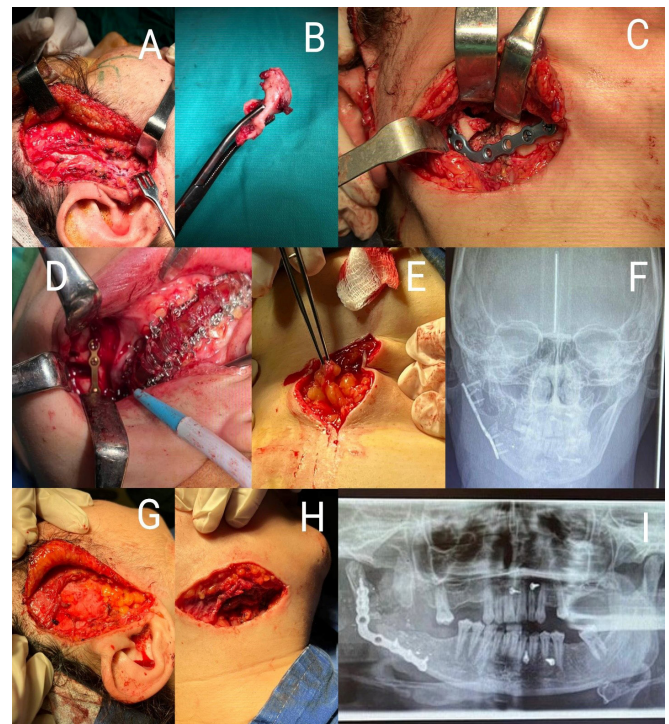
(A) Preauricular incision and access to the infratemporal fossa. (B) The mandible condyle after separating from coronoid process. (C) reconstructing condyle to the mandible corpus using reconstruction palate. (D) closed reduction maxillomandibular fixation. (E) Harvesting fat graft from abdominal dermis. (F) A post-Operative posteroanterior radiography. (G) Filling the preauricular region by the fat autograft. (H) Filling the region of submandibular incision by the fat autograft. (I) A Post-operative panoramic radiography showing the reconstruction plate.
